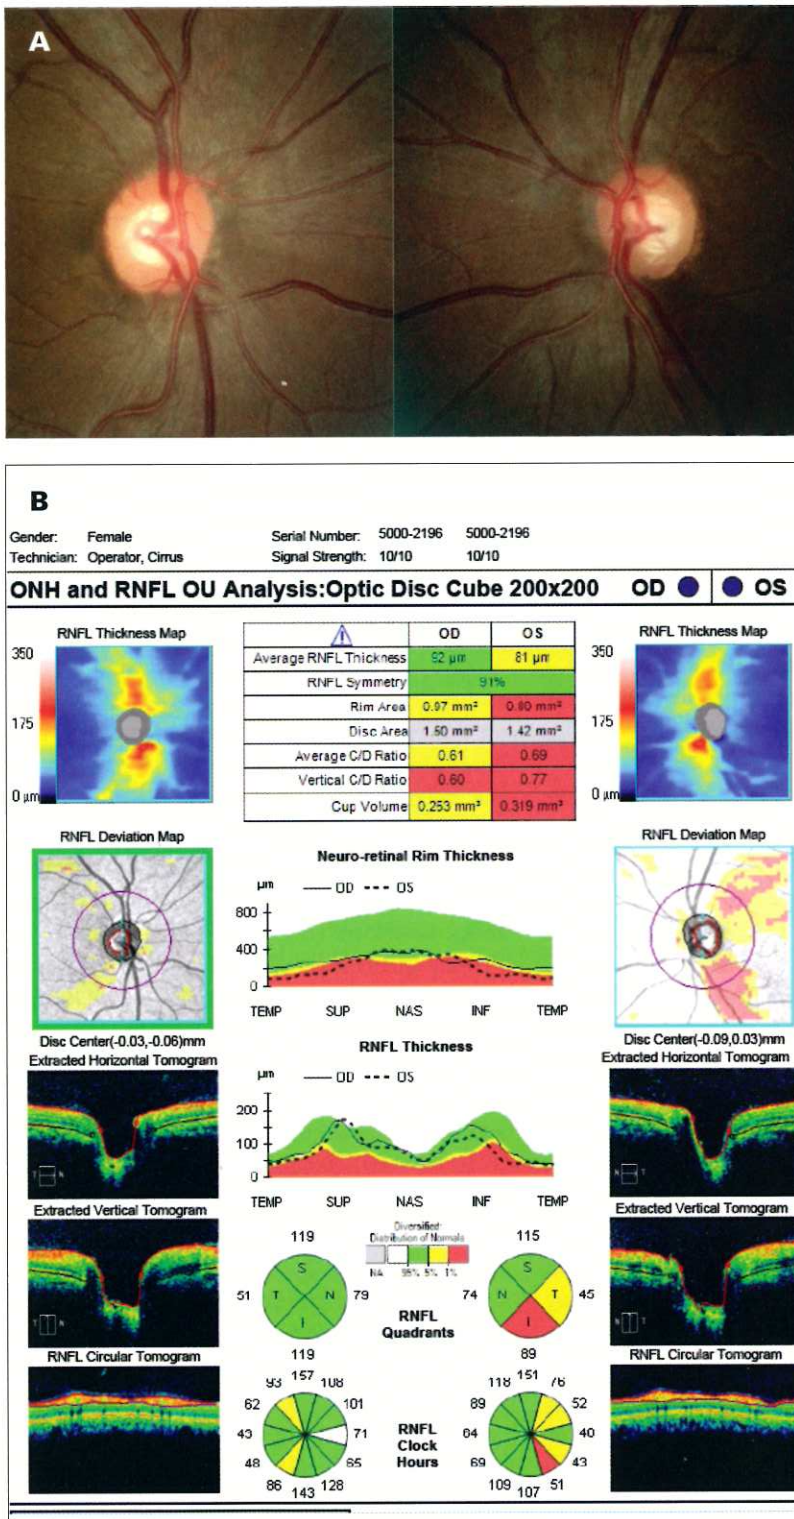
A 34-year-old female of Indian descent with no significant past medical or ocular history presents for glaucoma evaluation. She has a normal MRI of the brain and orbits. Over the past 9 years, she developed a progressive central scotoma OS with a corresponding wedge defect on the nerve fiber later. Figure 1A demonstrates the disc photos. Figure 1B demonstrates the baseline OCT data upon presentation.
